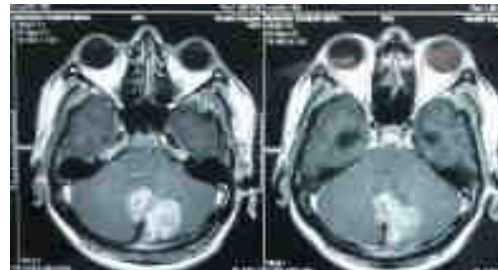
Contrast-enhanced Magnetic resonance images showing mass in the posterior fossa with heterogeneous contrast enhancement
